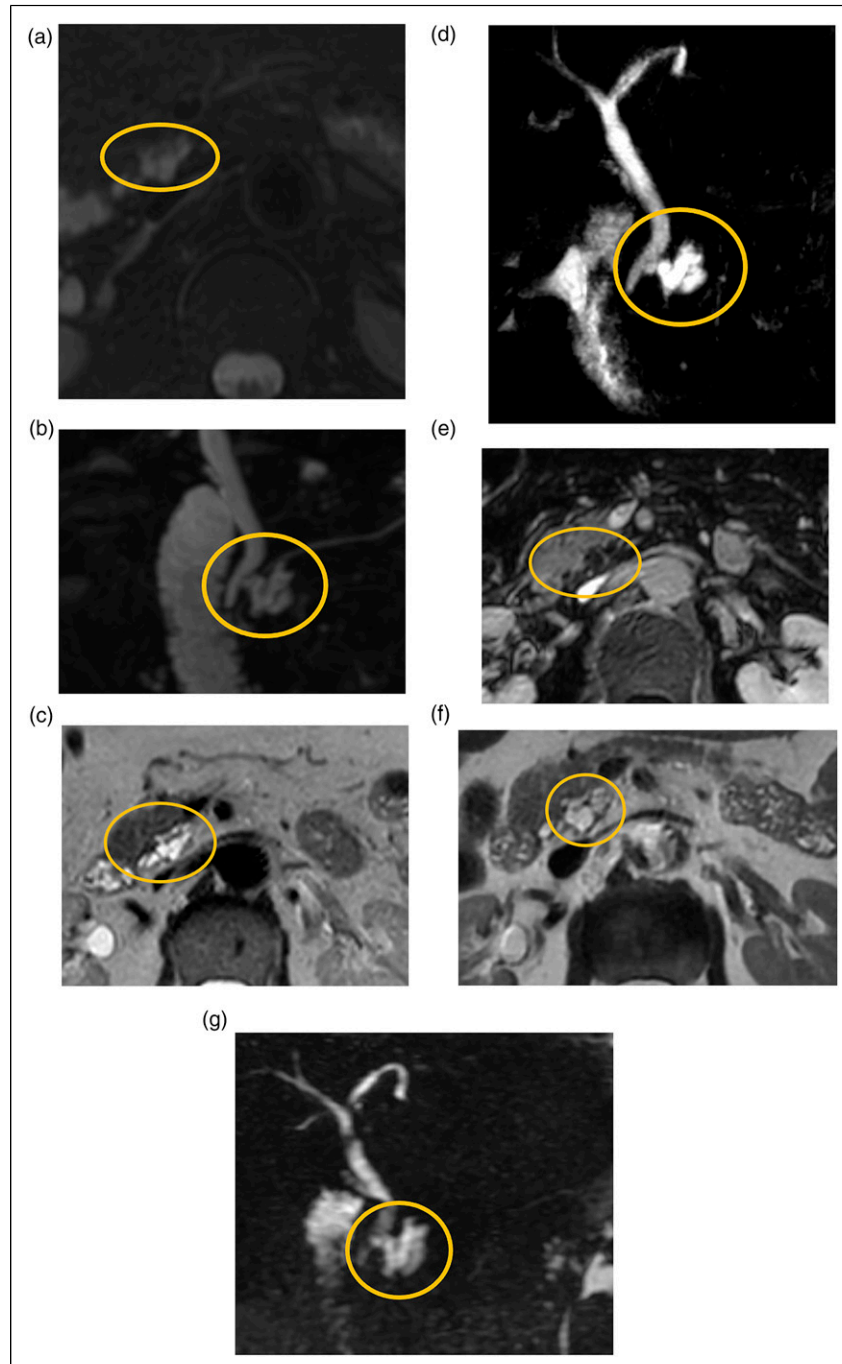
Sixty-seven-year-old female with a PCL at the time of initial MRI in 2015 (yellow circle). (A-B) Axial T2 fat-saturated and MRCP images from MRI 2015. Interim FNA [prompted by increase in lesion size] performed in January 2017 demonstrated mildly elevated amylase, normal CEA, and no malignancy. (C-E) Axial T2, MRCP, and axial T1 post-gadolinium images on MRI preceding FNA. (F-G) Axial T2 and MRCP images on final follow-up MRI. As per the last clinical note, optimal follow up had been achieved as per CAR guidelines with absence of worrisome features and due to patient age on the last follow-up (73 years). Recommended follow up with primary care provider. PCL: Pancreatic cystic lesions; MRI: magnetic resonance imaging; FNA: Fine needle aspiration.
